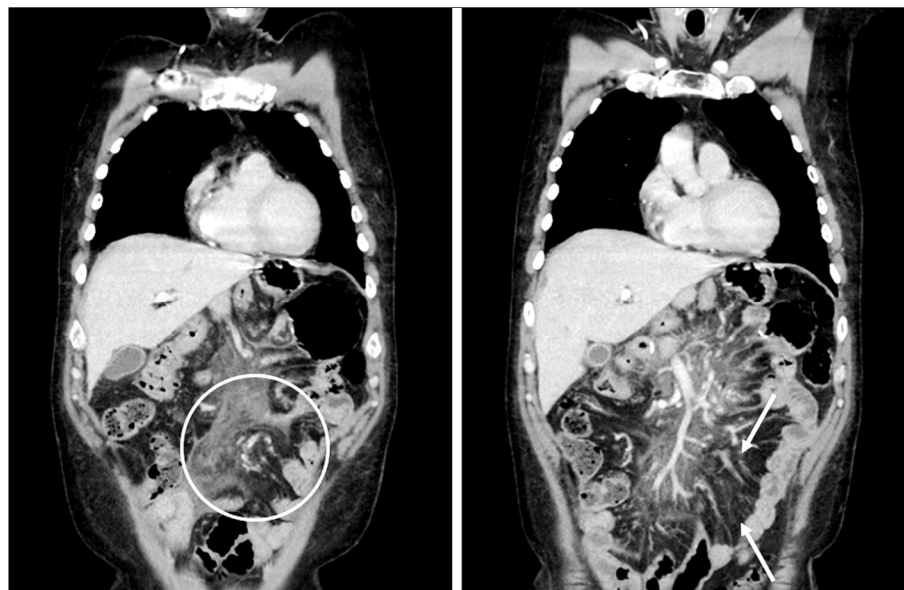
Coronal reconstructed CT-scan images showing a volumous mass extending along the mesenteric root (white circle), with several mesenteric and lumbo-aortic adenopathy (white arrows)
